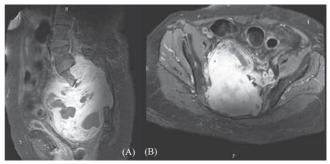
(A) and (B) The T1-weighted MR imaging with contrast identified a large, intense, enhanced soft tissue mass involving the sacral body. The tumor extended posteriorly to the lumbar spinal canal and lamina, and protruded into the presacral and pelvic cavity, causing compression and displacement of the uterus and urinary bladder anteriorly, and the retrosigmoid colon to the left laterally.
